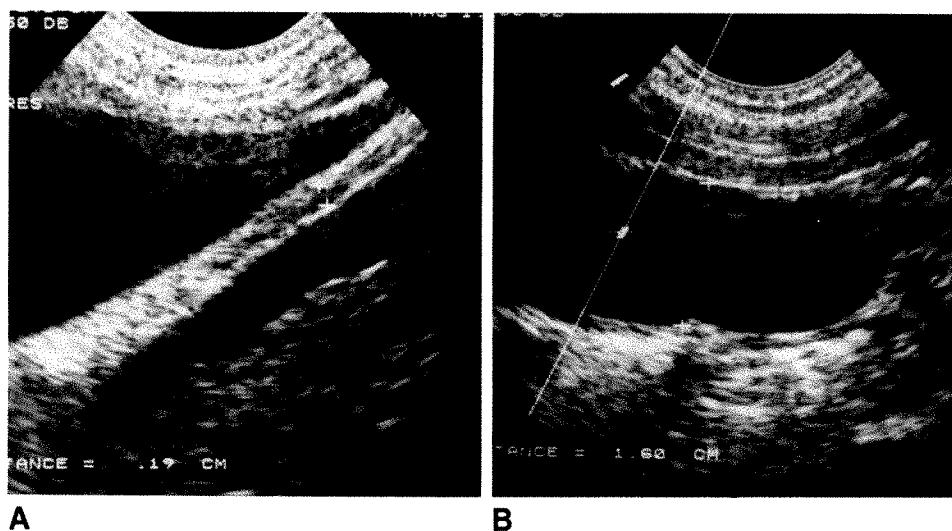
A, Longitudinal sonogram shows a small paraumbilical vein (between cursors). Vessel is more easily seen in extrahepatic portion of ligamentum teres, which is surrounded by ascites.
